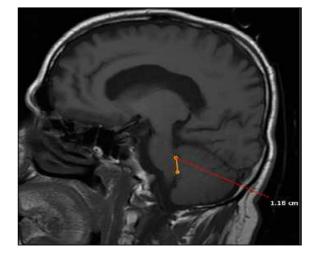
T1-weighted sagittal MRI image showing measurements of the middle cerebellar peduncle (MCP) width.
